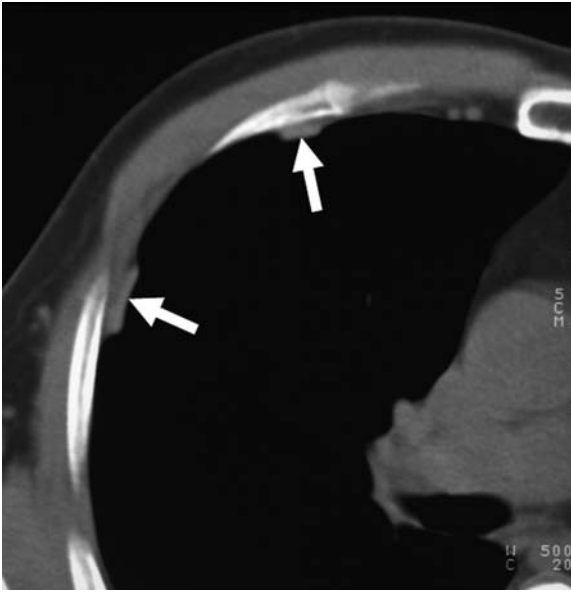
Computed tomography scan of the chest shows anterior and lateral pleural plaques appearing as a discrete smooth line of soft tissue attenuation (*arrows*)
